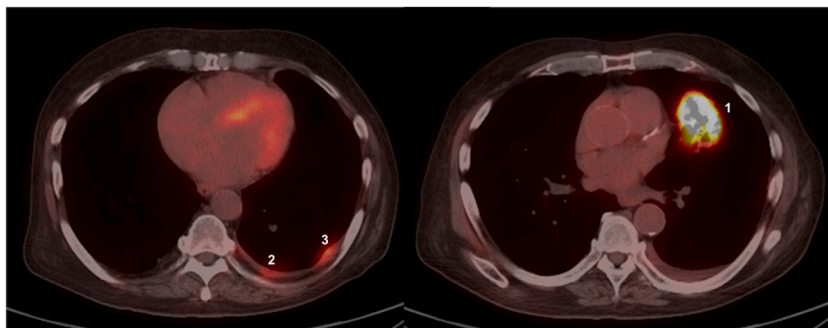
Positron emission tomography-computed tomography. Three areas with hypermetabolic activity [1]: Lung mass in the left upper lobe [2]; posterior FDG-avid nodule [3]; posterolateral FDG-avid nodule.
